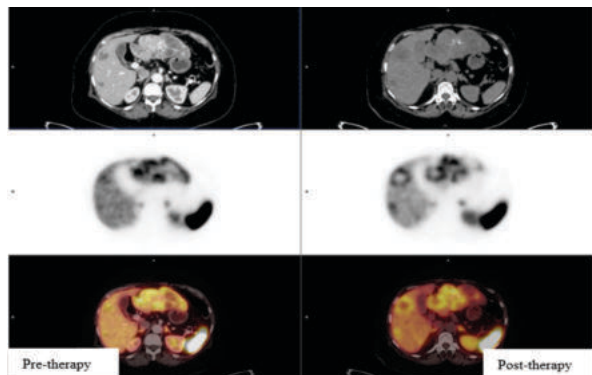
DOTA PET-CT scan shows increased SSTR expression in liver lesions.
